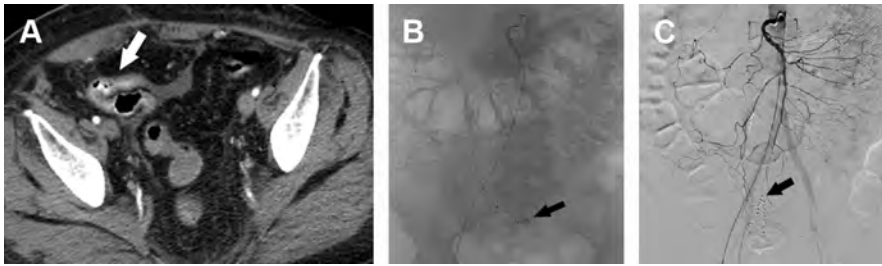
CTA and DSA of active GI bleed. A 65-year-old woman with recurrent lower GI bleeds, without identifiable source despite extensive workup, presents with hematochezia. Axial image from a CTA (A) demonstrates active GI bleeding within the small bowel (*white arrow*). DSA of the superior mesenteric artery (SMA) (B) demonstrates small focus of extravasation in the pelvis (*black arrow*). Note the embolization clips from prior treatment. DSA of the SMA (C) after embolization demonstrates no evidence of contrast extravasation (*black arrow*).
